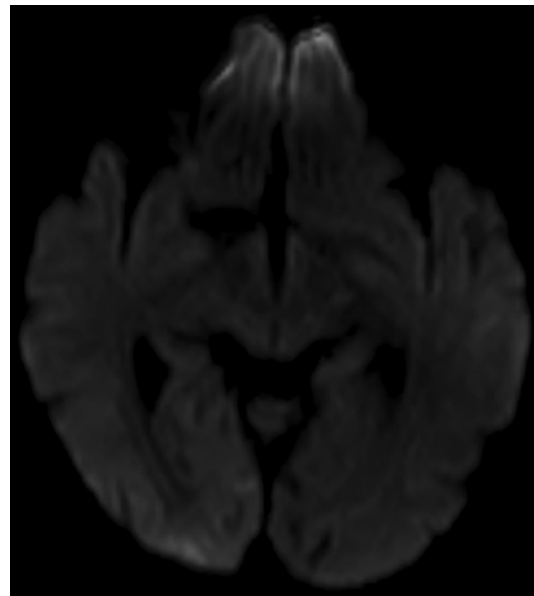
Right occipital gyriform DWI hyperintensity.
